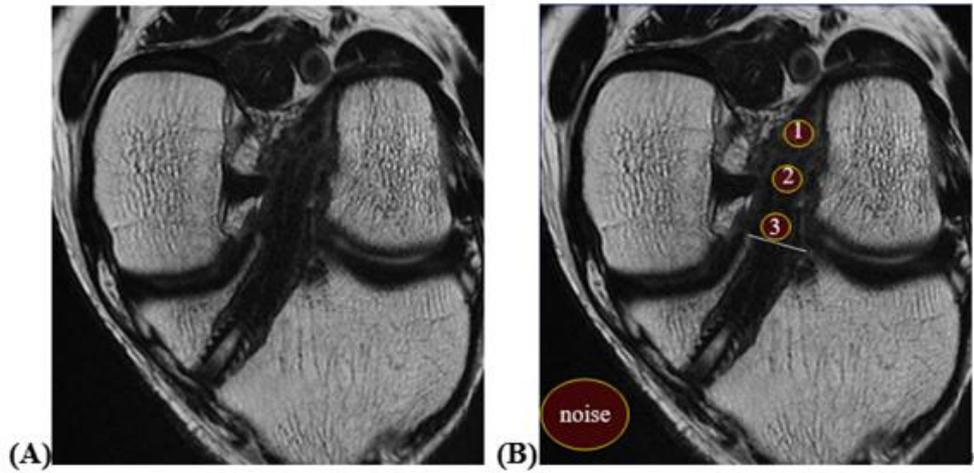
Subtraction image in contrast-enhanced MRI. Proximal (1), middle (2), distal (3) regions were chosen on sagittal view, and ROIs of each region were measured on reverse oblique coronal view.
